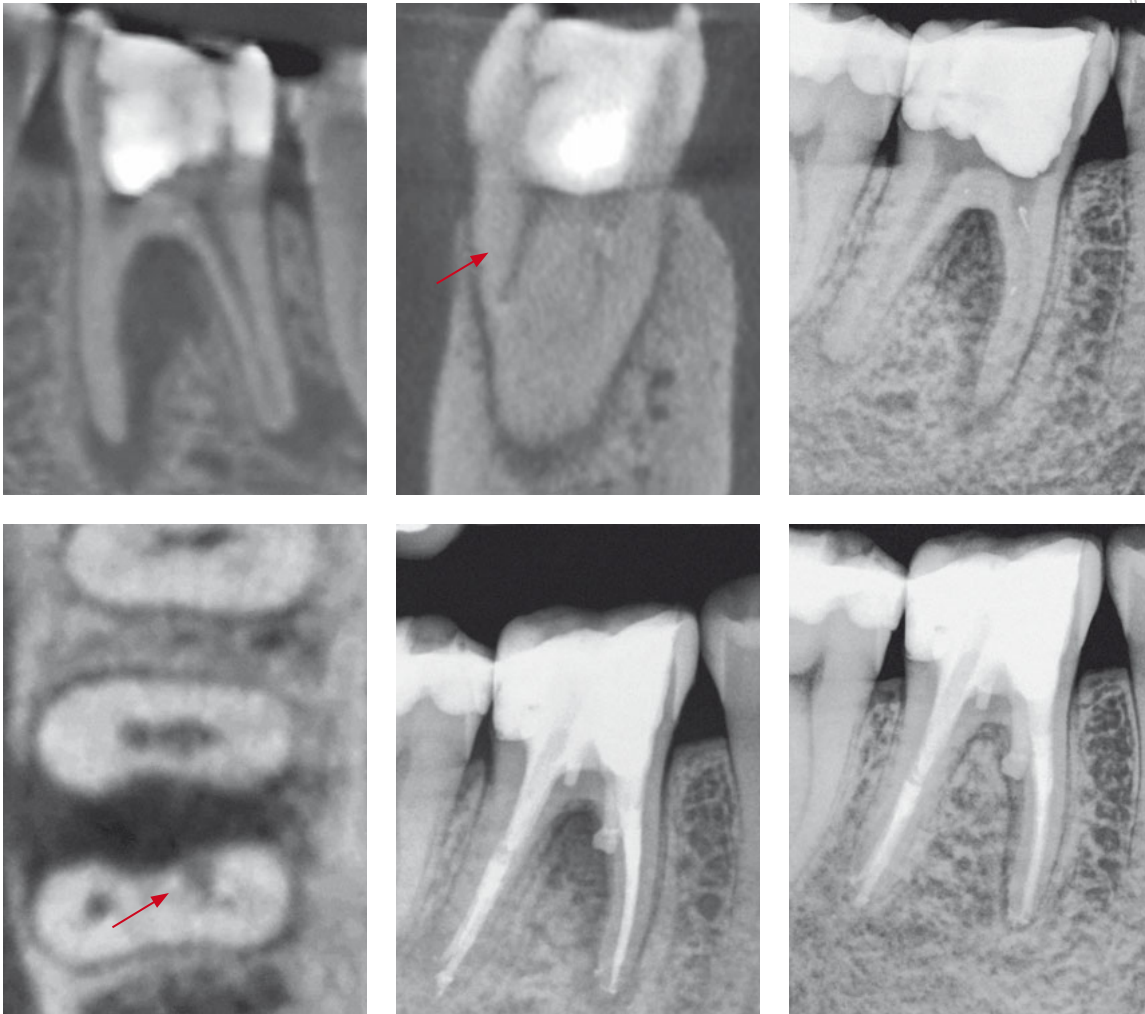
Tooth 46: The intraoral radiograph reveals an interradicular radiolucency in the area of the mesial root (top right). The entire extension of the interradicular lesion and the presence of the periapical lesions can be seen only on the sagittal plane images of the cone beam computed tomography imaging (top left). The transverse plane images (top middle) show that during the attempt to access and shape the mesiolingual canal, the original course was not respected (arrow). The axial plane images (bottom left) reveal the perforation in the interradicular region, as well as the original course of the canal (arrow). Following shaping and cleaning of the original canal with the help of CBCT, the sealing of the perforation and root canal filling (bottom and middle), which is an obvious reduction of the radiolucency, is apparent on the subsequent 2D control radiograph. This image is courtesy of Dr Michael Arnold, Dresden.
